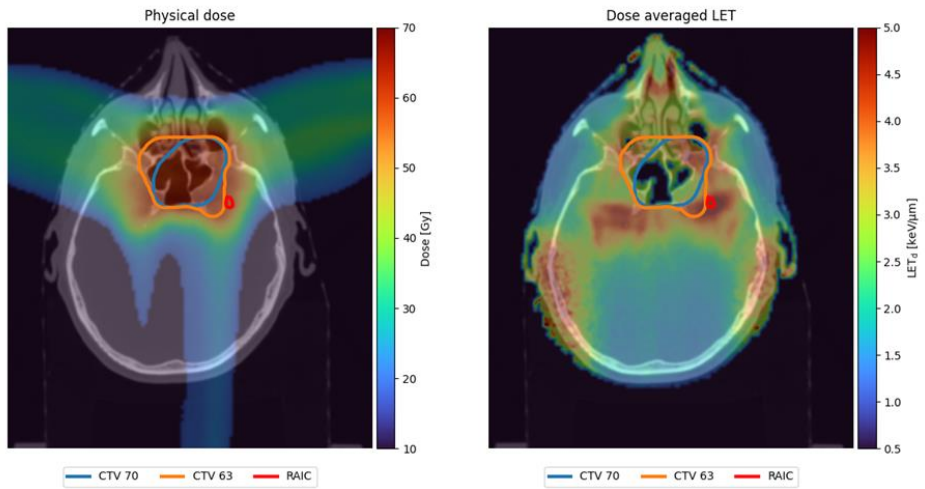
Dose- and LET_d distribution. RAIC (red contour): Contrast enhancement from $T1_w$ MRI sequence.
